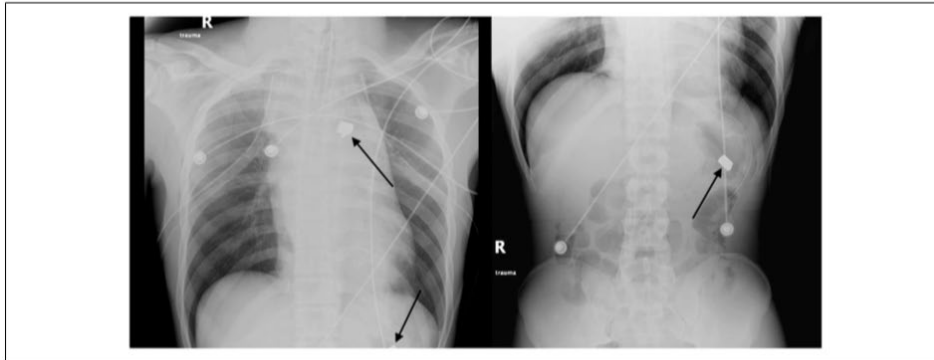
Radiographic imaging taken during the trauma resuscitation revealing mediastinal widening and foreign bodies consistent with bullets in the mediastinum and abdominal left upper quadrant.
